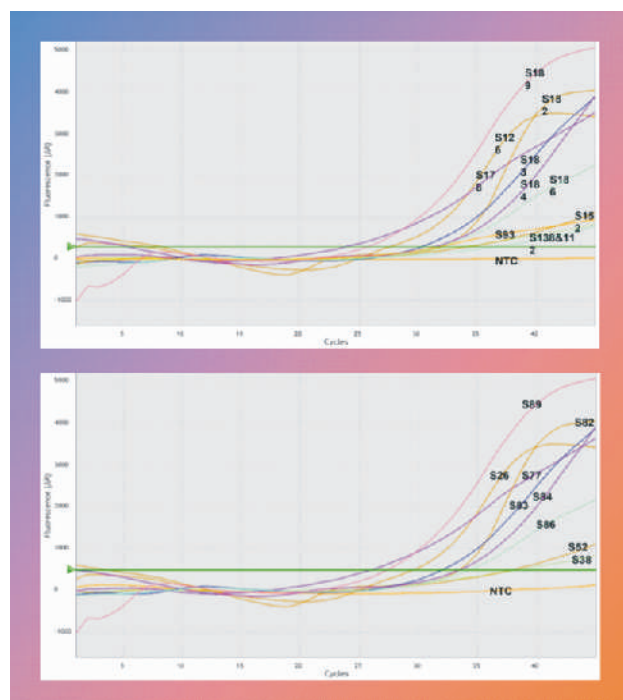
Optics graph shows RT-PCR of human Rhinovirus B results using FAM fluorescent dye. according to (threshold=417.525):- positive samples no. are 15, 26, 38, 52, 77, 82, 83, 84, 86, 89, 93, 111, 126, 138, 152, 178, 182, 183, 184, 186, and 189 with CT values of 24.17-33.66. No amplification in no template control (NTC).
